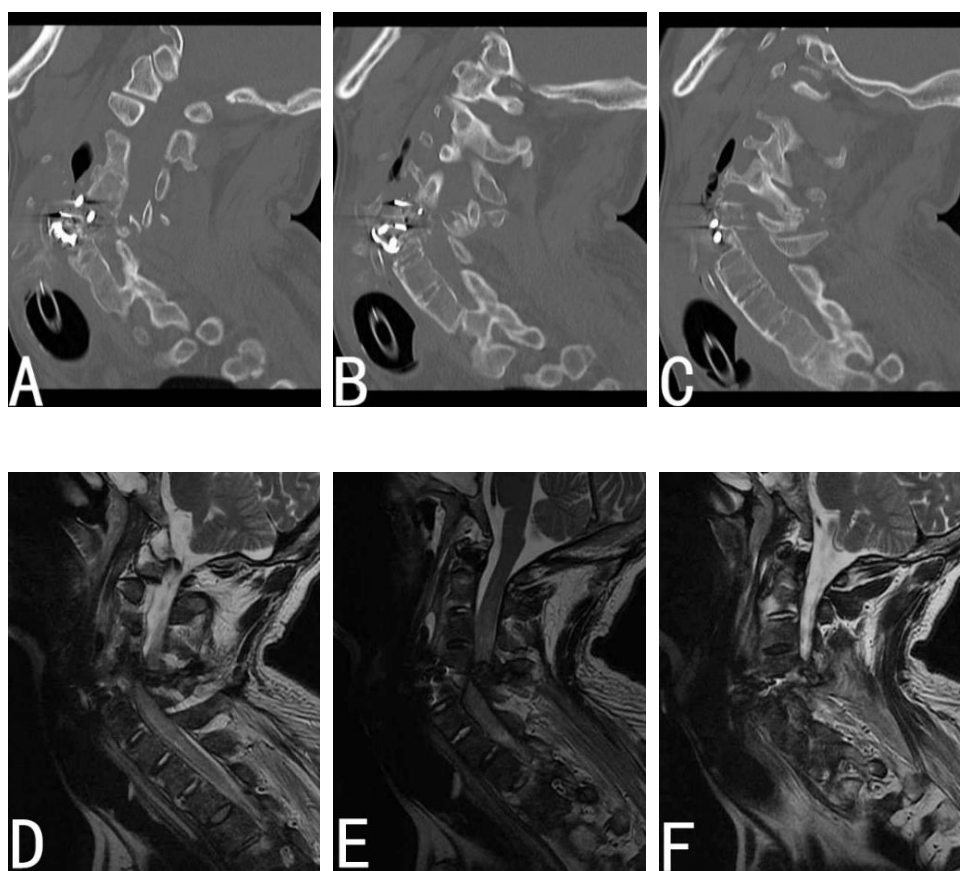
Loosening of internal fixator with the first anterior approaches (A-C). Preoperative T2-weighted MR image reveals spinal cord compression (D-F).
